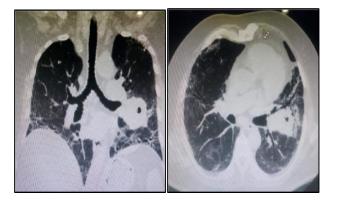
The consolidation seen on the left side of lung along with bilateral ground glass opacities in HRCT scan.
